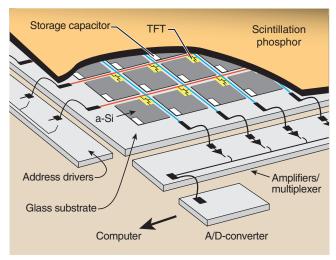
Digital radiographic images can be produced from the cesium iodide (CsI) phosphor light detected by the active matrix array (AMA) of silicon photodiodes.
